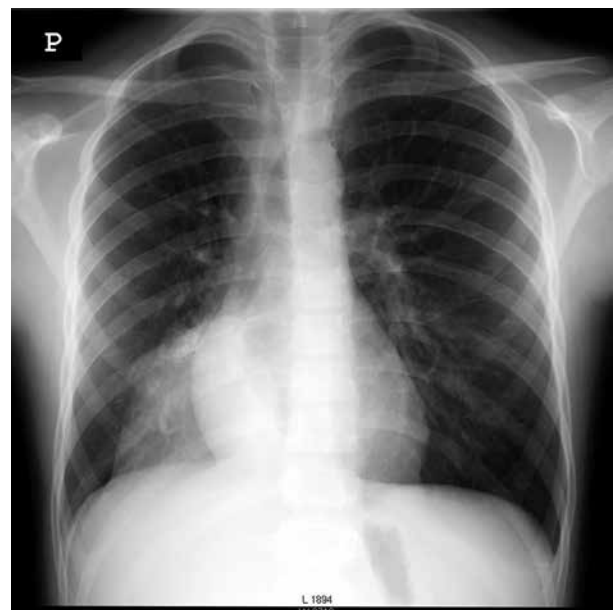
Chest radiography of the inflammatory myofibroblastic tumor of the lung. Massive atelectatic-inflammatory changes in the right lower lobe
